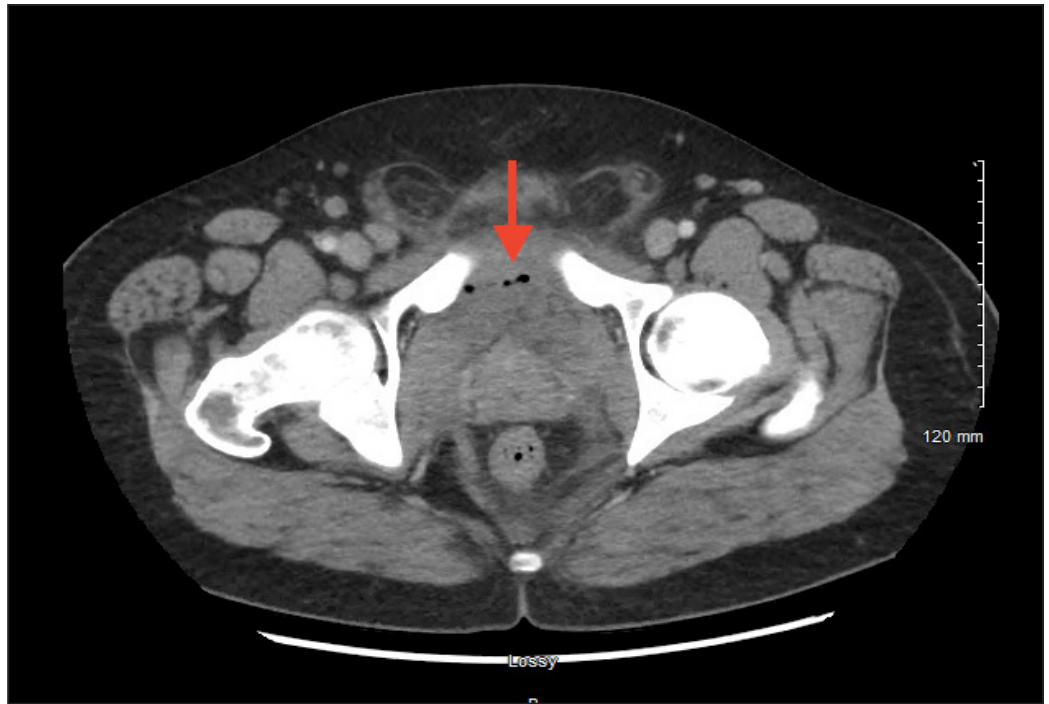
Approximately 5 cm fluid and gas collection on axial CT in the prevesicular Space of Retzius
